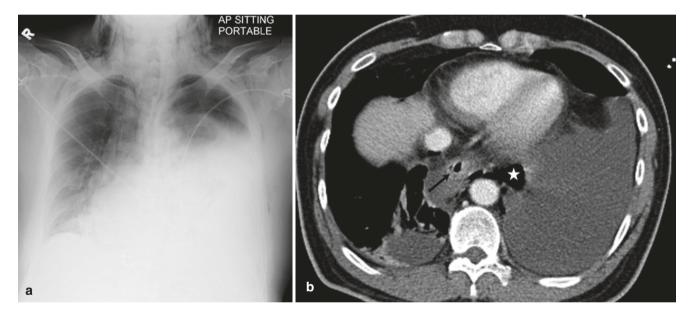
Boerhaave syndrome. (a) Frontal chest radiograph shows bilateral pleural effusions, left pneumothorax, and subcutaneous emphysema. (b) Axial CT image shows a large air pocket (asterisk)
